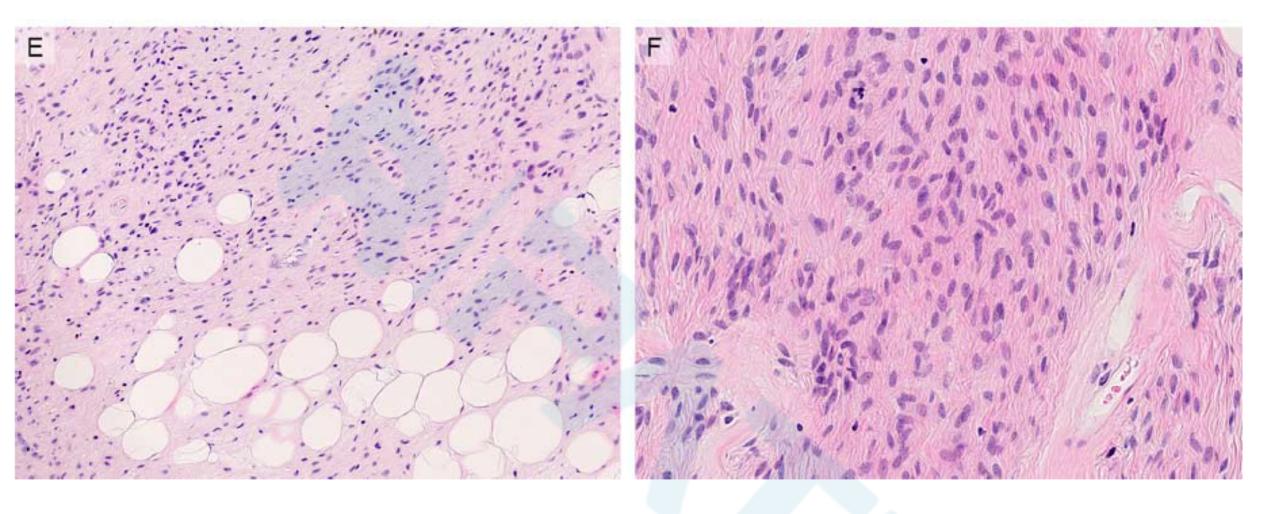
Features of a tumor with PRRX1-KMT2D/KMT2D-PRRX1 fusions. A, The axial T1-weighted image magnetic resonance showed a sharply demarcated intermuscular soft tissue mass dorsomedial of the knee. B, Macroscopically, the tumor had a firm consistency with a yellowish cut surface and was surrounded by a pseudocapsule. C, The tumor was predominantly hypocellular with bland spindle cells without a distinct growth pattern within a fibrillary collagenous matrix. D, It showed prominent perivascular hyalinization.
